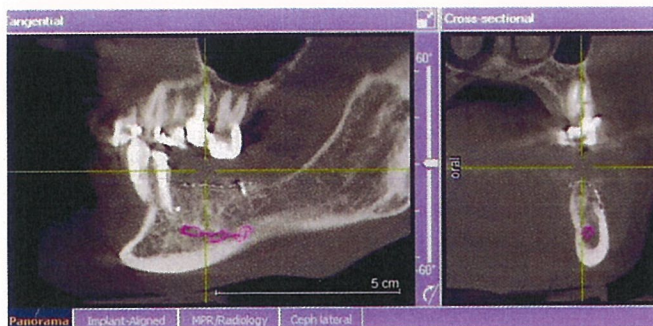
CBCT of # 19 site showing a complete bone fill in both vertical and horizontal direction.
